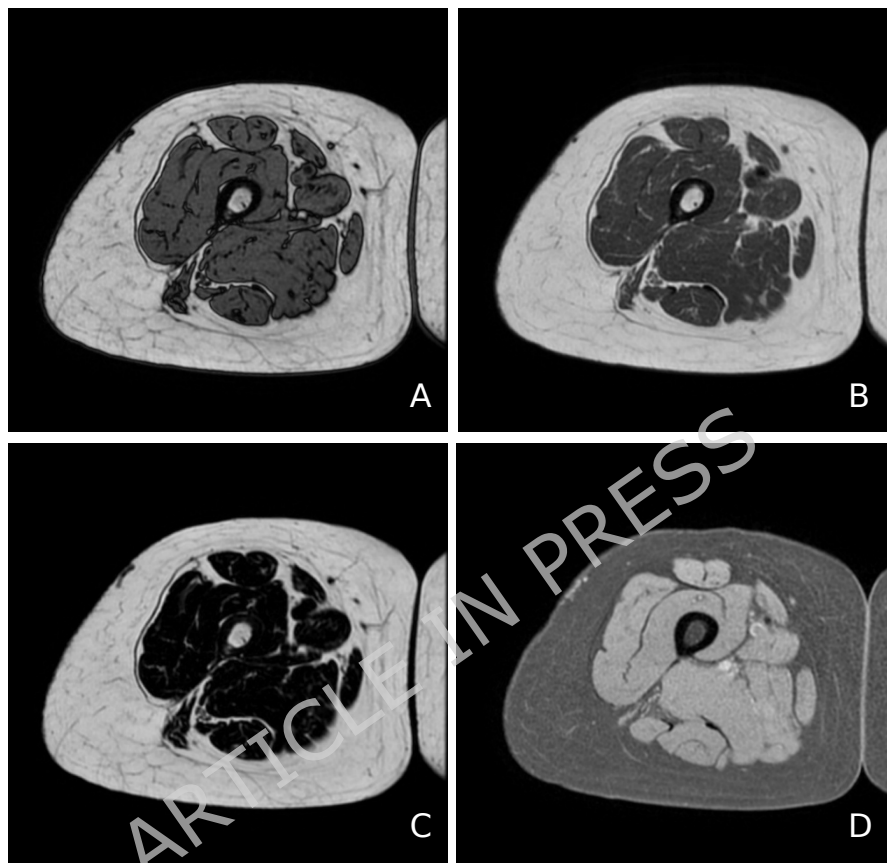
Dixon magnetic resonance imaging of the right thigh in an 82-year-old woman. Axial images include out-of-phase T1-weighted (A), in-phase T1-weighted (B), fat-only (C), and water-only (D) reconstructions. Dixon sequences enable accurate separation of fat and water signals, allowing quantitative assessment of intramuscular fat infiltration (myosteatosis) and muscle composition.
